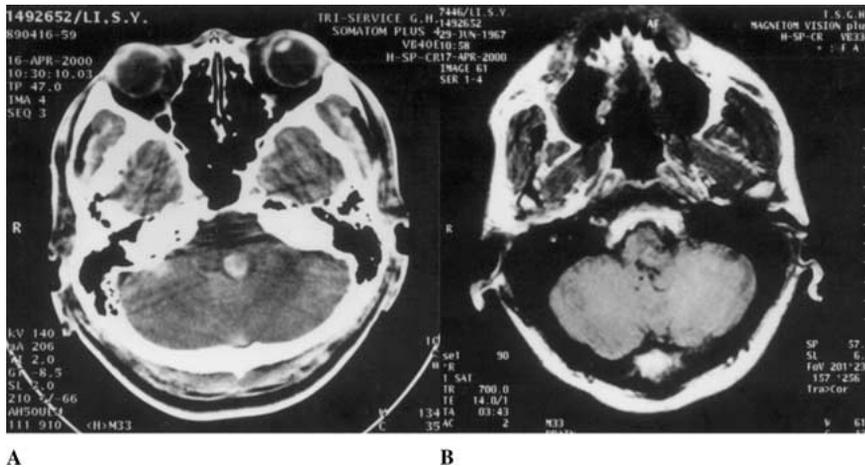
A Preoperation cranial computed tomography shows a hematoma in the left posterior pons. B The postoperation magnetic resonance imaging of the head reveals an arteriovenous malformation in the left pontomedulla.
